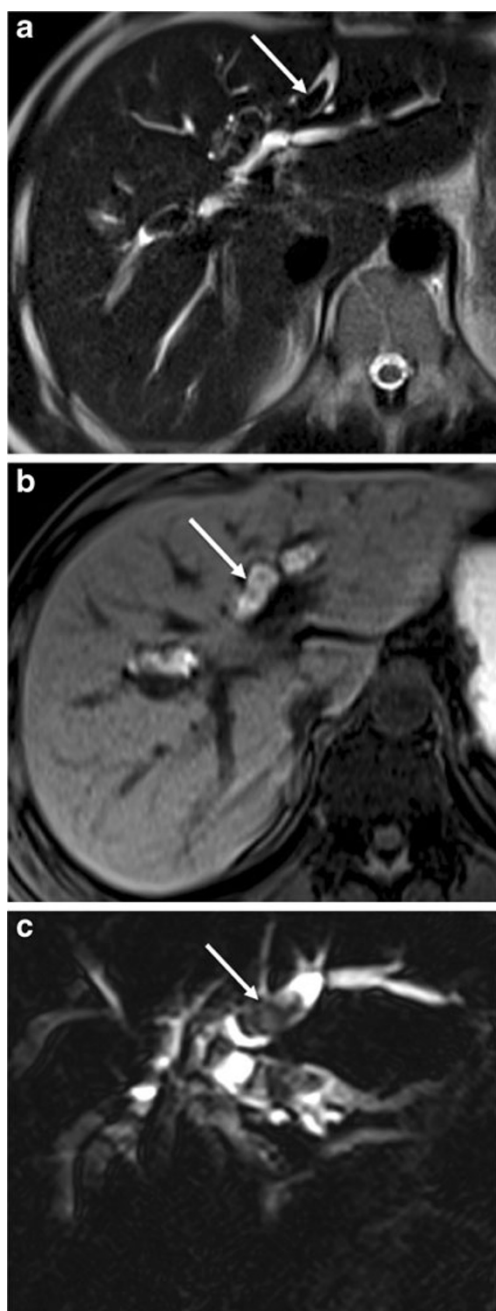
Diffuse global bile duct abnormalities in a 48-year-old man with LPAC syndrome. Transverse T2-weighted acquisition (a), transverse T1-weighted acquisition with fat saturation (b), and coronal maximum intensity projection MCRP (c) show a biliary dilatation in both right and left lobes containing biliary stones depicted as T2 hypointense and T1 hyperintense endoluminal formations (*white arrow* in a and b). The MCRP shows large oval shape signal voids in the dilated bile ducts (*white arrow* in c) corresponding to biliary stones
